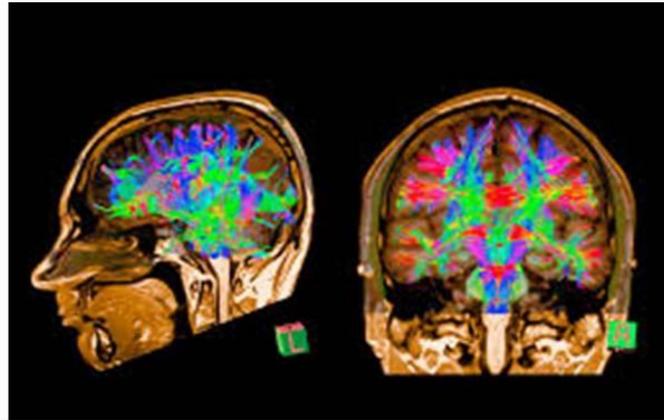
Diffusion tension imaging MRI or tractography follows the flow of H<sub>2</sub>O within the axons of neurons.
